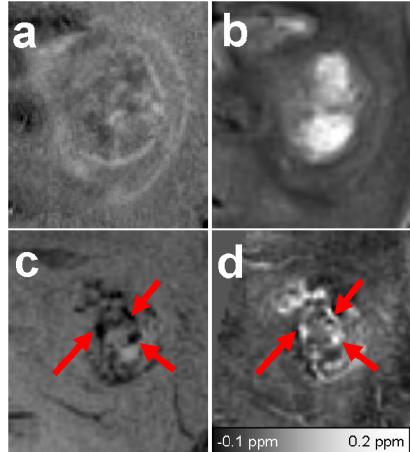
Corresponding sections of MR images of a 72-year-old man with a right temporal glioblastoma. The contrast-enhanced T_1 -w, FLAIR, SW, and susceptibility images are shown in (a), (b), (c), and (d), respectively. Arrows indicate ITSS.
